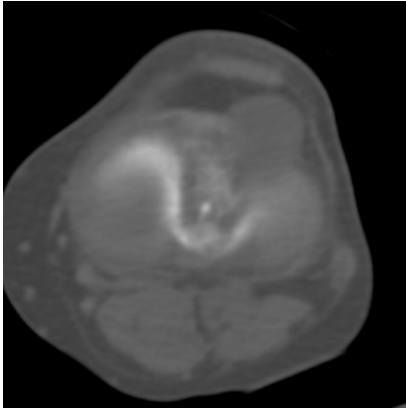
72-year-old man with giant-cell tumor of the tendon sheath. FDG PET/CT. Bone-windowed transaxial image from the noncontrast CT component shows a solid, soft-tissue-density, intra-articular mass, centered at the synovium.
